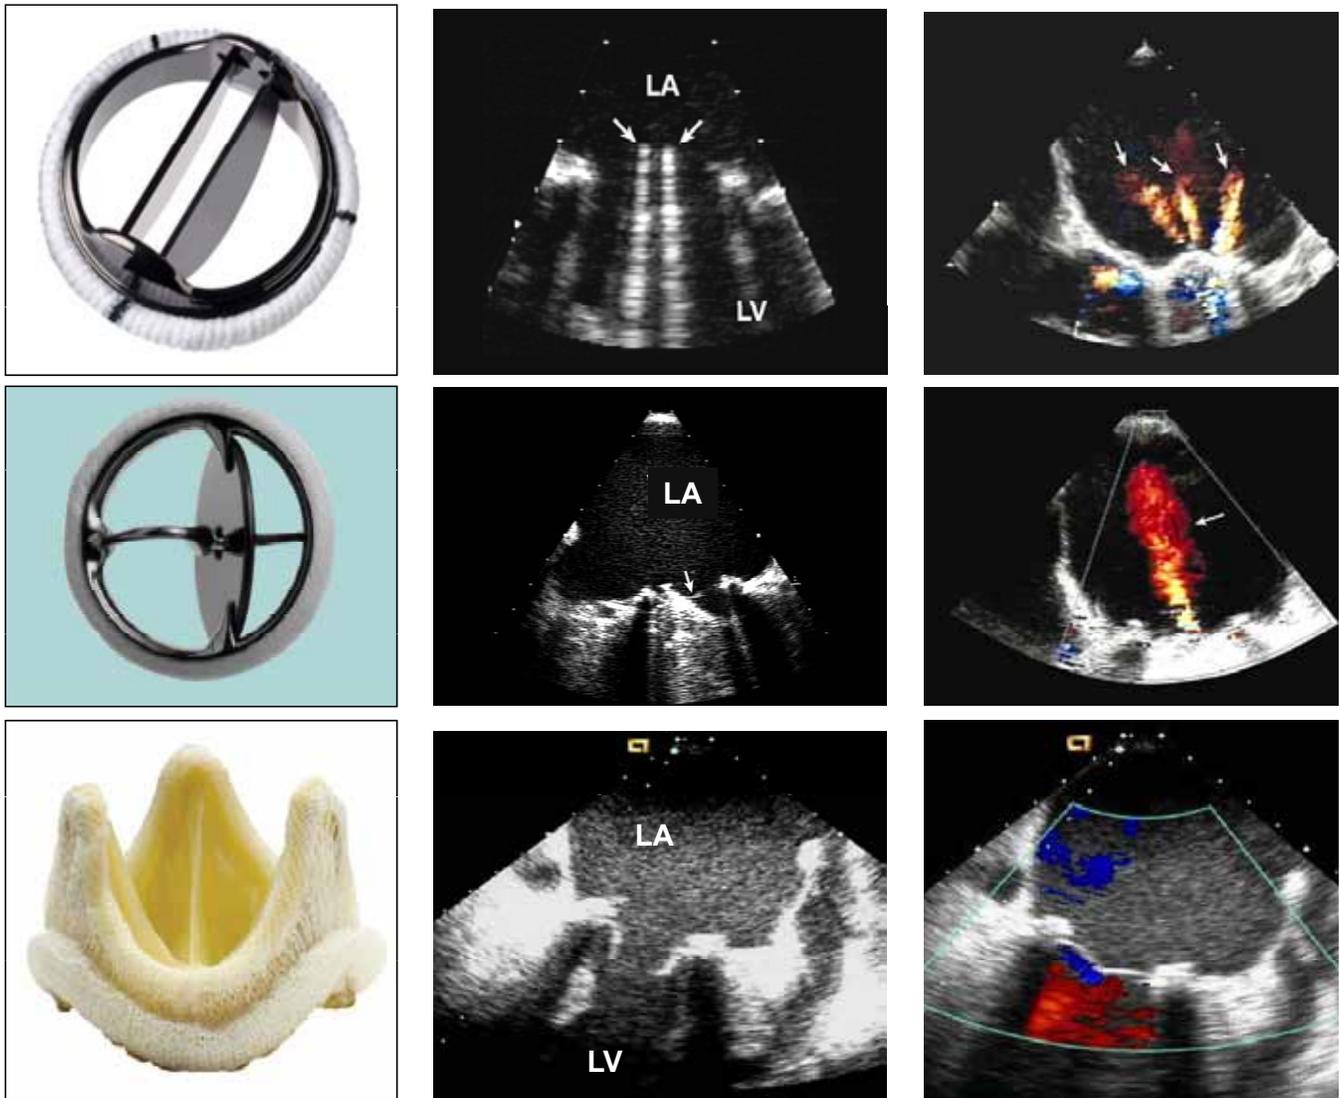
Examples of mechanical and bioprosthesis and their transesophageal echocardiographic characteristics taken in the mitral position in diastole (middle panels) and in systole showing physiologic regurgitation patterns. Modified from Zoghbi et al.¹
